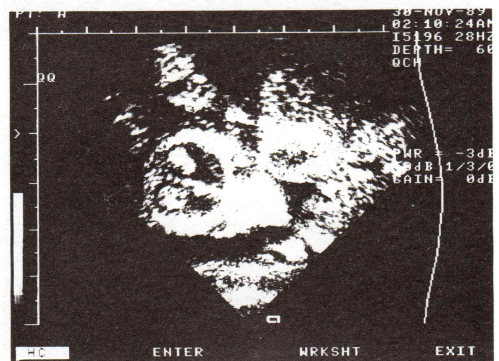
Transvaginal sonography demonstrates choroid plexus and details of fetal face at 11 weeks gestation.
